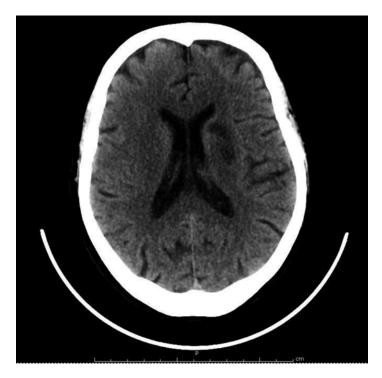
CT scan without contrast enhancement. Evidence of hypodense ischaemic lesion at the level of left anterior nucleus capsular and radiata area
